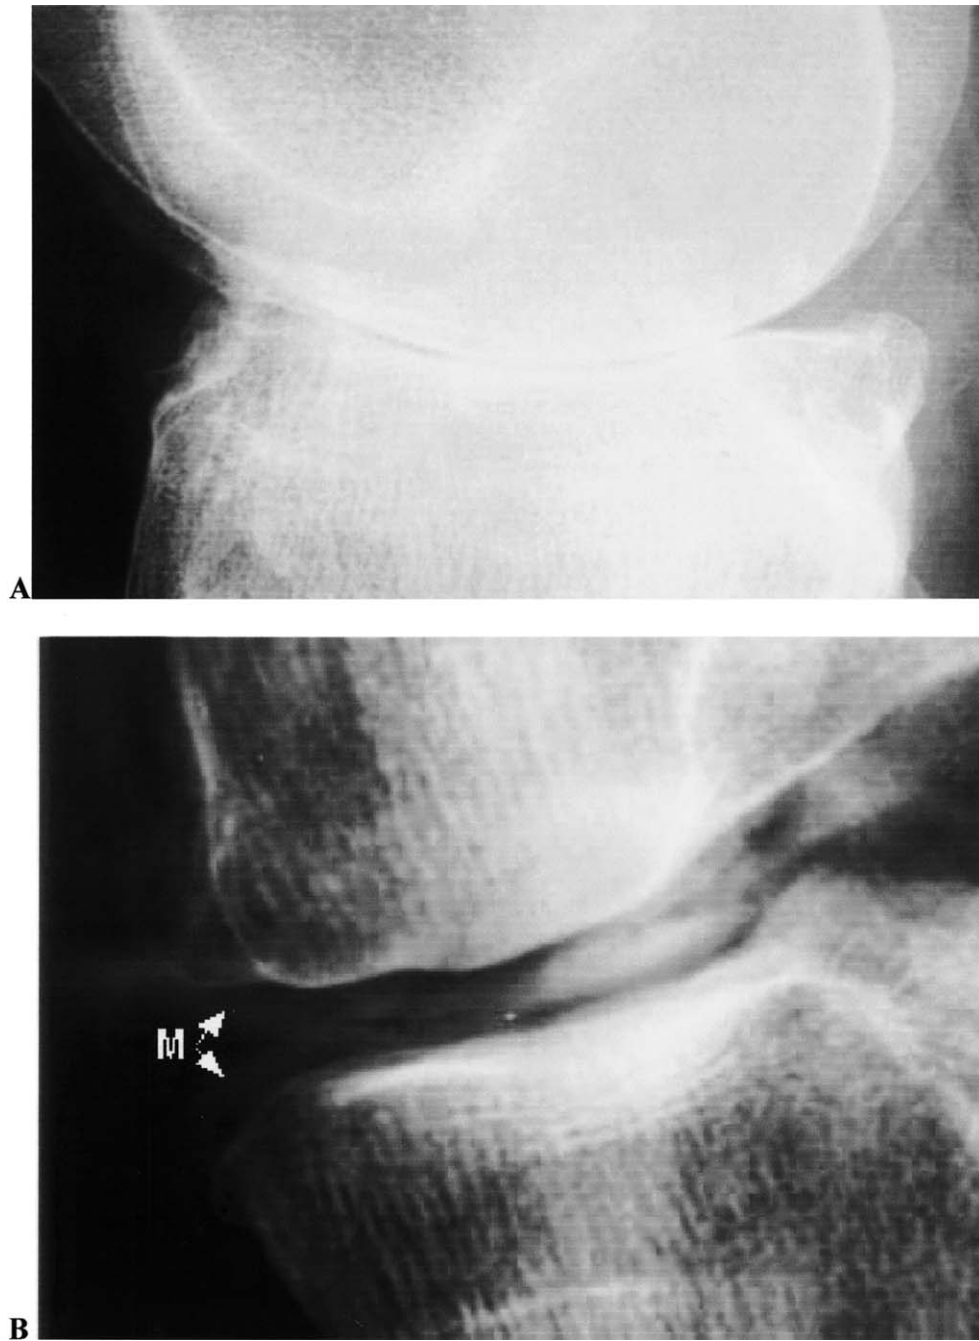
In the semiflexed position the femoral condyle occupies the central region of the tibial plateau. (A) is the same knee as in Fig. 2B radiographed on the same occasion in the semiflexed position confirming the absence of cartilage in this OA joint. (B) Double contrast macroarthrogram of an OA knee taken in the standing semiflexed position. In the medial diseased compartment the meniscus (M) is extruded so that the minimum joint space width measures only articular cartilage thickness.
